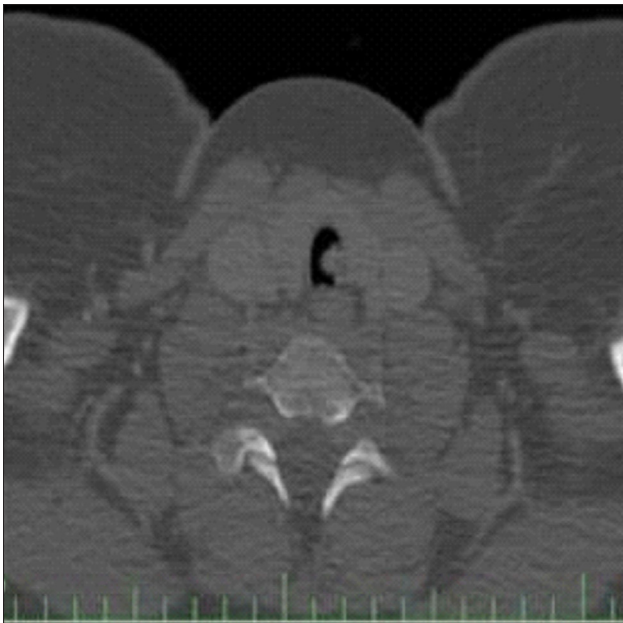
Tracheal lesion was observed on thorax computed tomography
